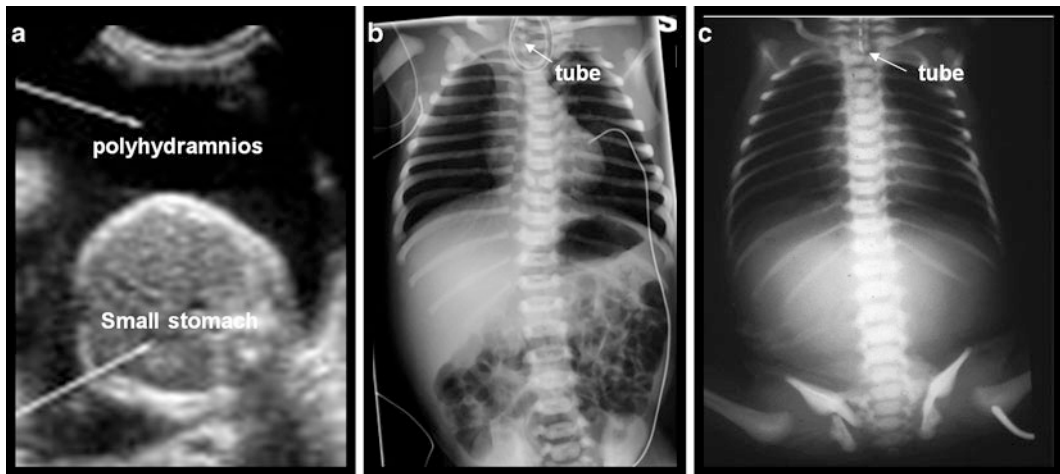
(a) Prenatal imaging of suspected TOF with polyhydramnios and small stomach. (b) Plain radiograph showing esophageal pouch tube and distal gas confirming
